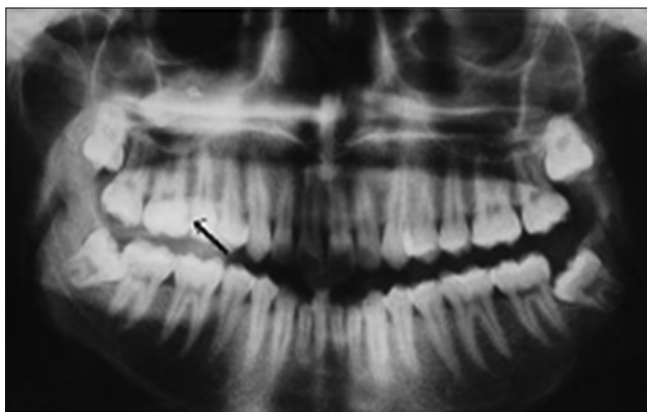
Panoramic radiograph in improved interproximal program
